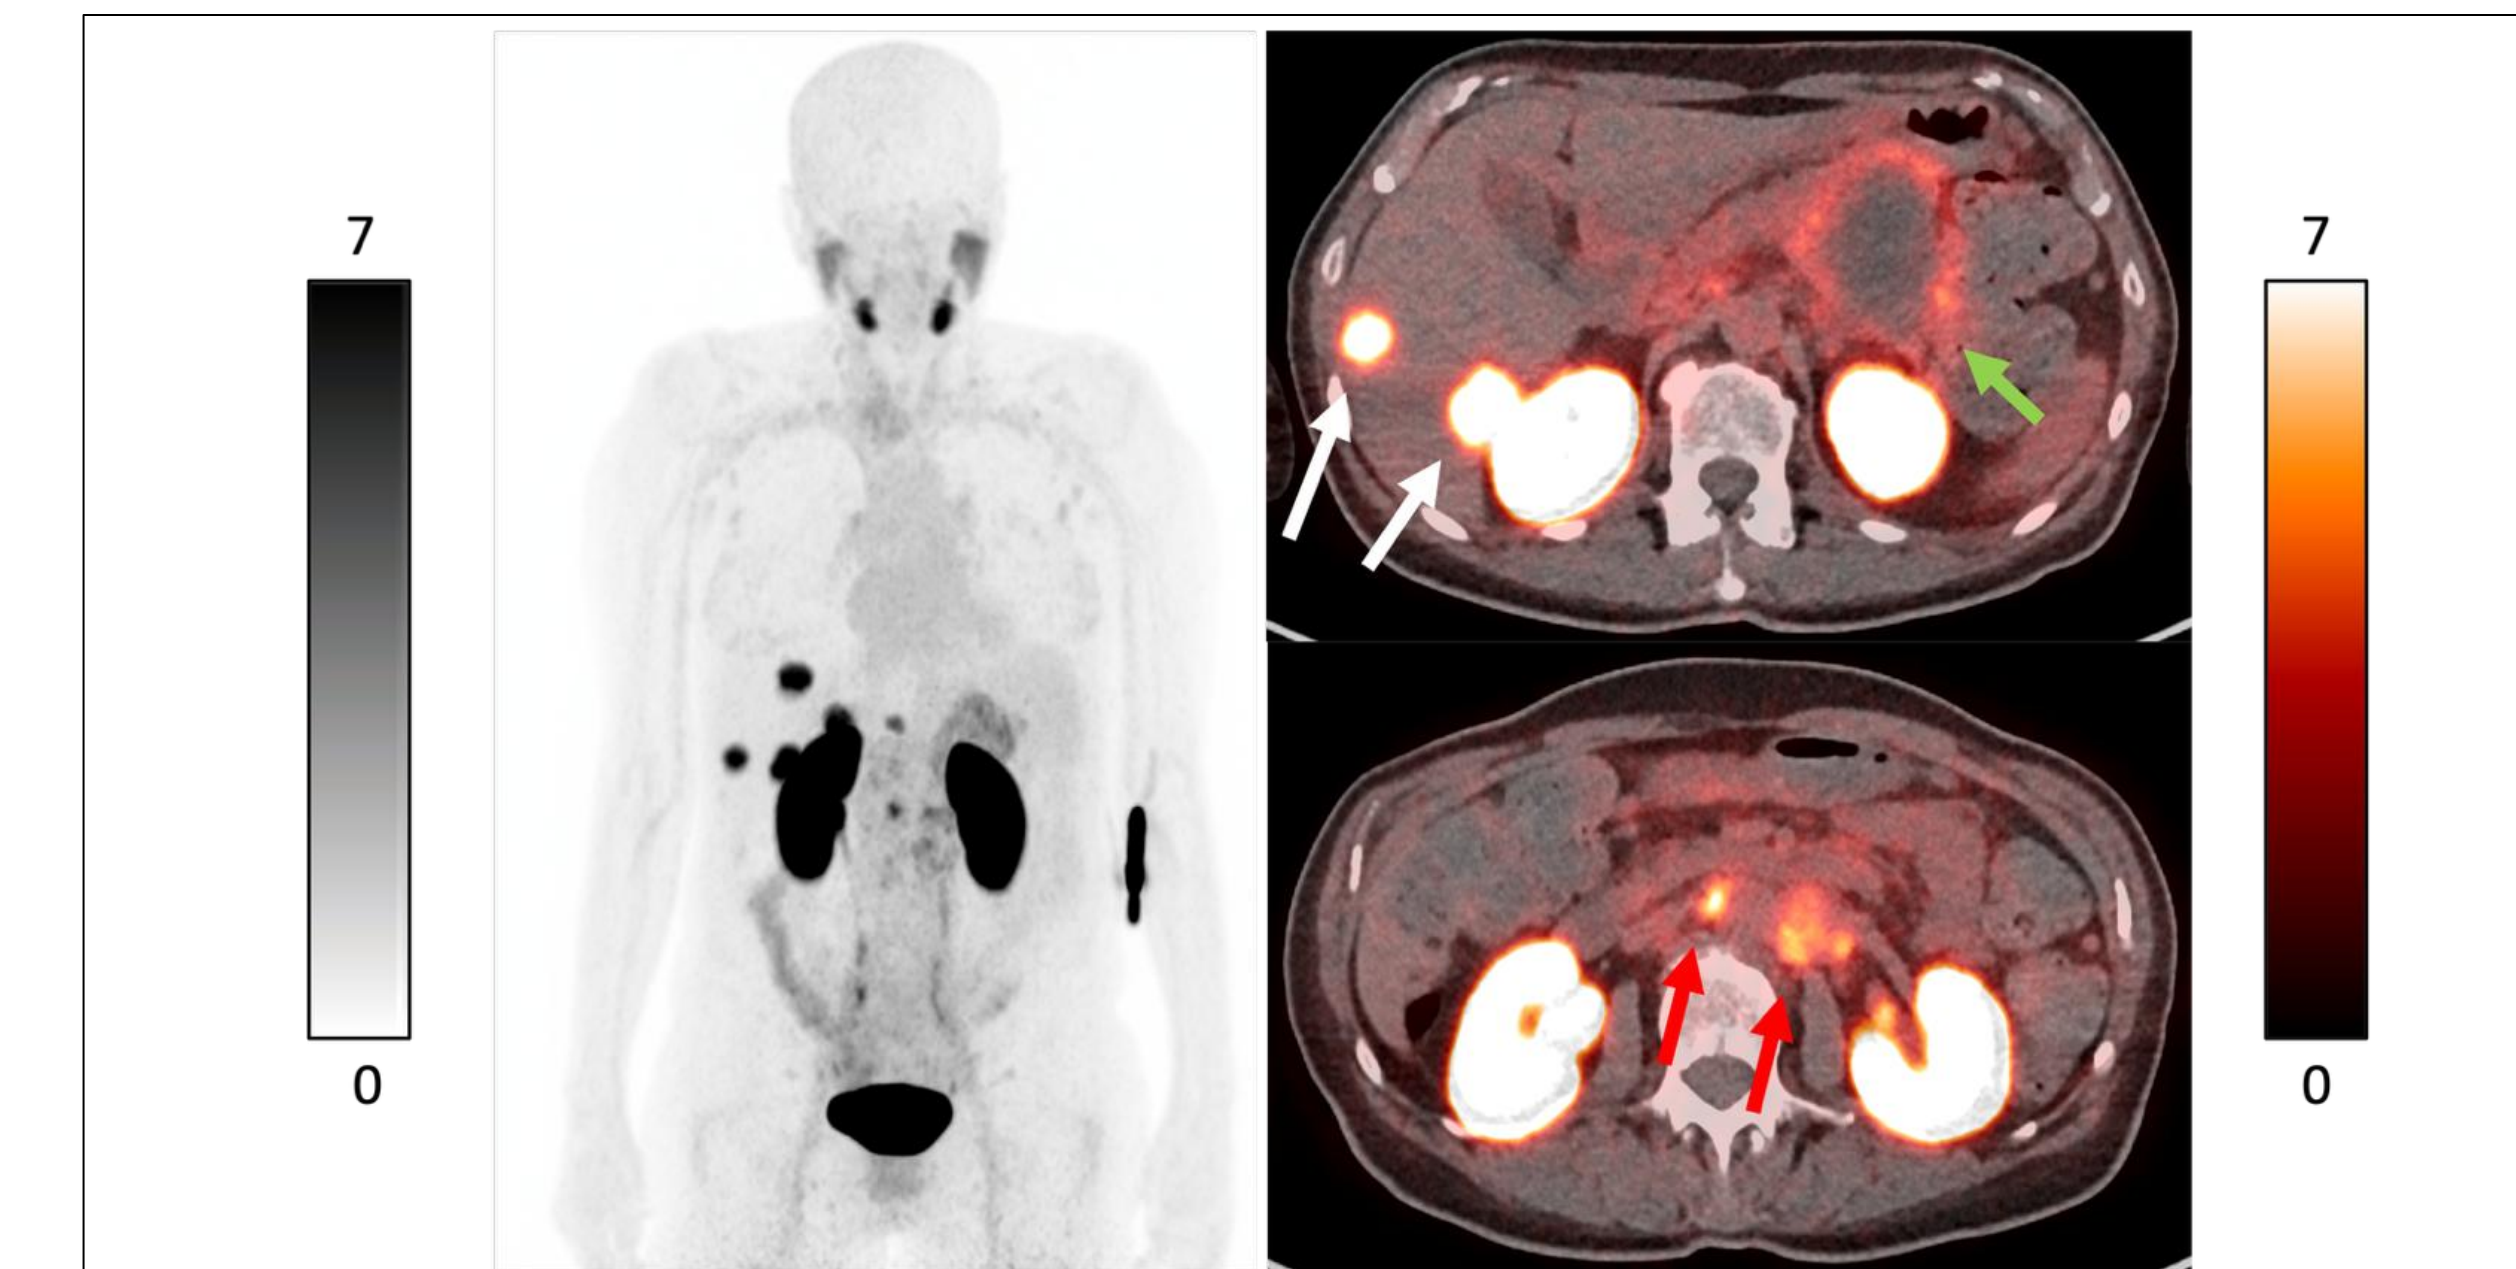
EphA2-PET/CT imaging in lymphonodal and hepatic metastasized pancreatic ductal adenocarcinoma. Maximum intensity projection (on the left side) acquired 45 minutes after injection of [⁶⁸Ga]Ga-BCY18469. Fused axial PET/CT images (on the right side) 45 minutes after injection of [⁶⁸Ga]Ga-BCY18469 showing pancreatic tumor mass (green arrow), hepatic metastases (white arrows) and lymphonodal metastases (red arrows).
